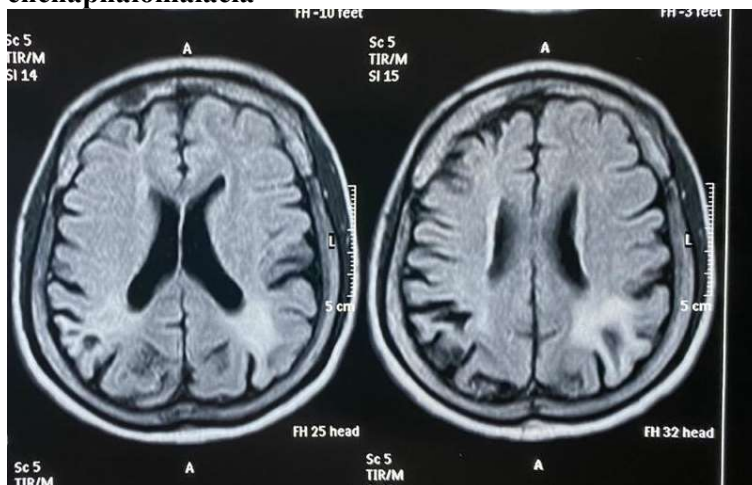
Axial FLAIR image of MRI showing post hypoxic left occipital encephalomalacia
